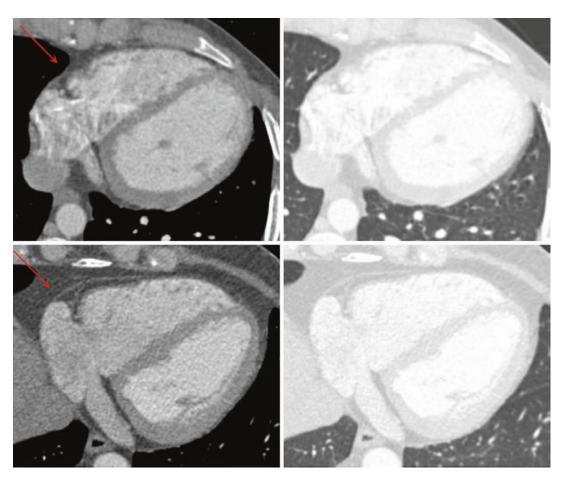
Axial computed tomography images in a patients with congenitally absent pericardium (top left and right panels), compared to a patient with normal pericardium (bottom left and right panels). Note insertion of lung
